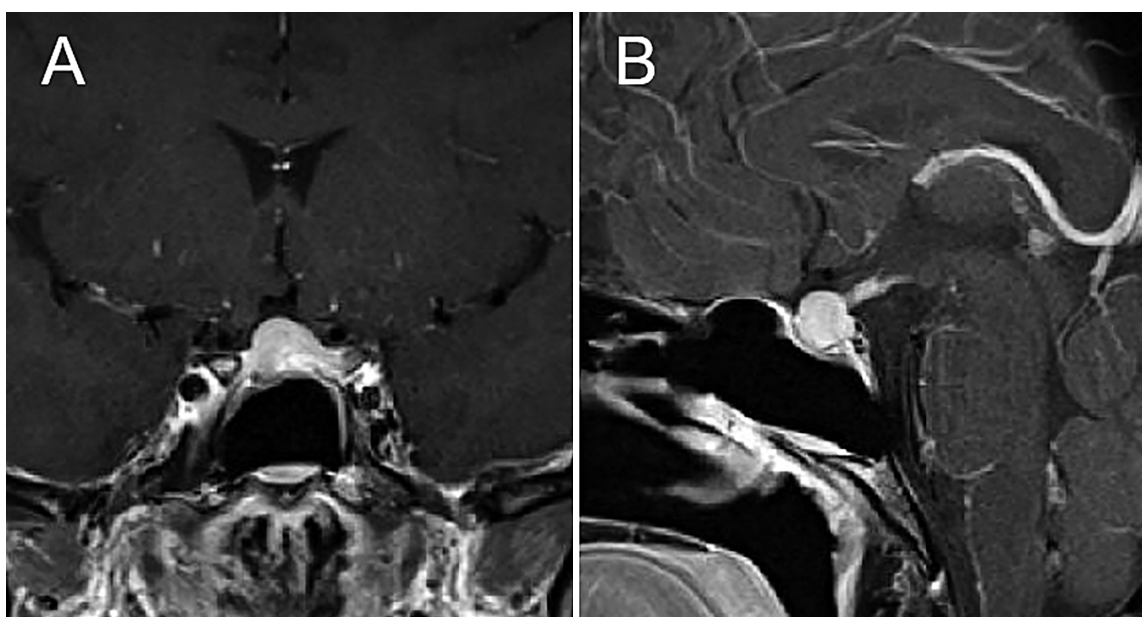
Postoperative MRI showing complete tumor extirpation (A, B).
